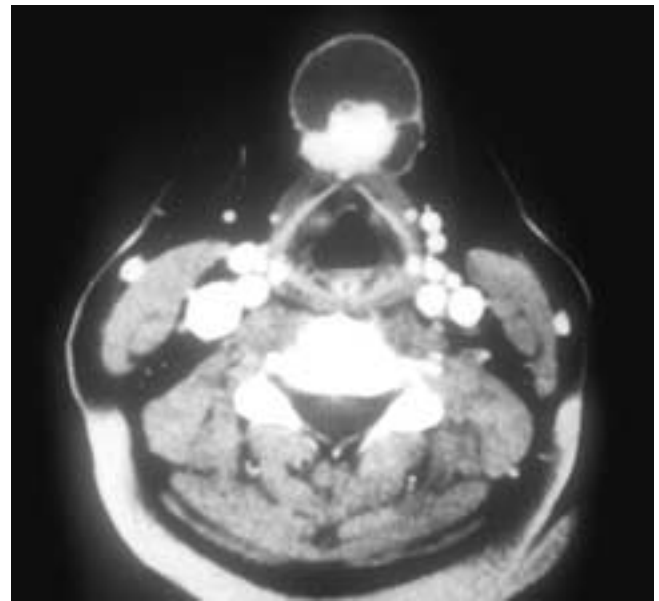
Axial contrast-enhanced CT scan shows a midline cyst just caudal to the level of the hyoid bone. Within the cyst is an enhancing nodule and there is some infiltration of the adjacent strap muscles. This was a papillary thyroid carcinoma within a thyroglossal duct cyst. At surgery, there was extension of the tumor into the strap muscles.
